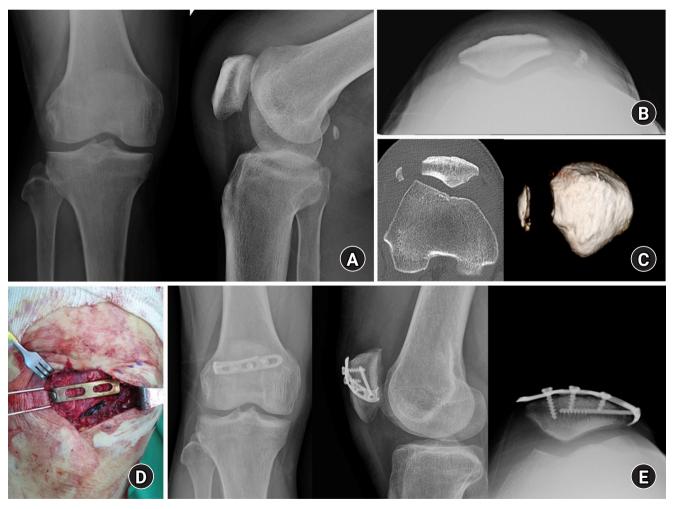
Lateral marginal fracture with a small fragment. (A) Right knee anteroposterior and lateral views showing no definite fracture. (B) Skyline view revealing medial subluxation of the patella. (C) Knee computed tomography showing a small lateral fragment. (D) Hook plating. (E) Postoperative 1-year X-ray showing union, with a Lysholm score of 94.
